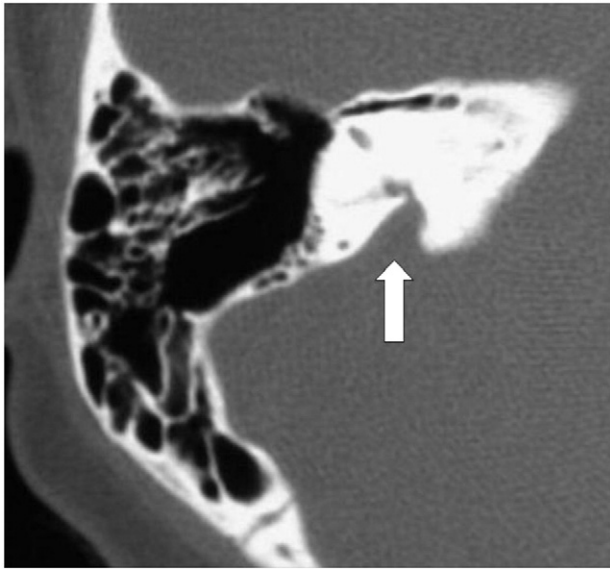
An EVA (arrow) is shown in the axial high-resolution CT of the right-side temporal bone.
